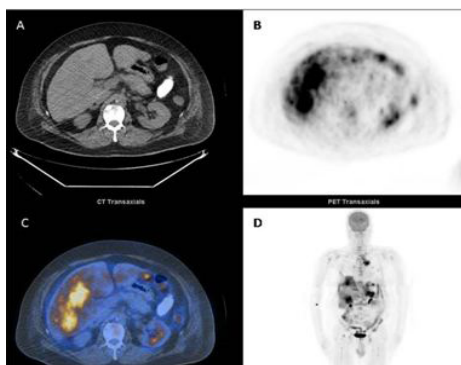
PET/CT of 56 year old male with bronchogenic carcinoma. Non-contrast CT scan (a) shows areas of subtle hypo density. Multiple hepatic metastases seen on PET image (b), fused PET/CT image (c) and MIP image (d)
